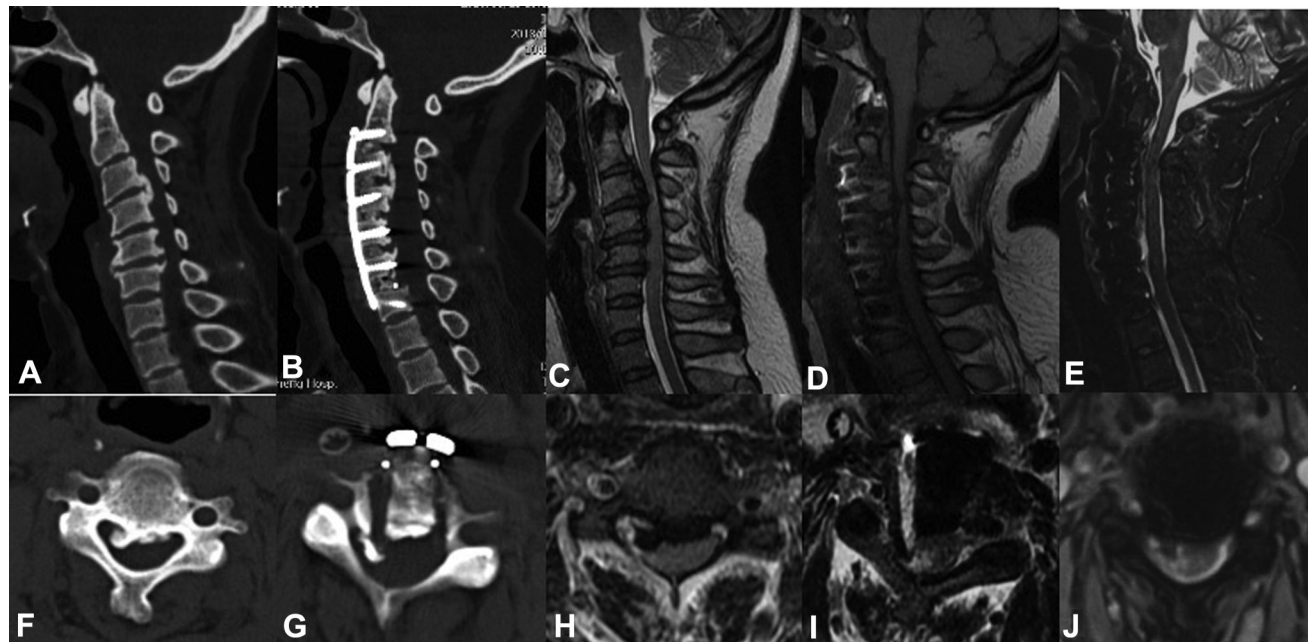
Radiologic data of case 2. (A) Preoperative sagittal CT scan showed ossification of the posterior longitudinal ligament from C3 to C6. (B) Postoperative sagittal CT scanning showed antedisplacement of the VOC from C3 to C6 and the PROM at C3/4. (C) Preoperative sagittal MRI showed compression of the spinal cord from C3 to C6 caused by OPLL. (D) Postoperative sagittal MRI showed insufficient antedisplacement of OPLL at C3/4 and obvious edema of the spinal cord. (E) Six-month follow-up sagittal MRI showed that the spinal cord was still compressed at C3/4, but the edema diminished. (F) Preoperative cross-sectional CT scanning showed ossification of the posterior longitudinal ligament at C3/4. (G) Postoperative cross-sectional CT scanning showed antedisplacement of the VOC at C3/4 with postoperative remaining ossification mass in the spinal canal. (H) Preoperative cross-sectional MRI showed compression of the spinal cord at C3/4 caused by OPLL. (I) Postoperative cross-sectional MRI showed remaining compression and edema at C3/4. (J) Six-month follow-up cross-sectional MRI showed that the compression at C3/4 persisted and the edema revealed. CT, computed tomography; MRI, magnetic resonance imaging; OPLL, ossification of the posterior longitudinal ligament; PROM, postoperative remaining ossification mass; VOC, vertebrae-OPLL complex.
